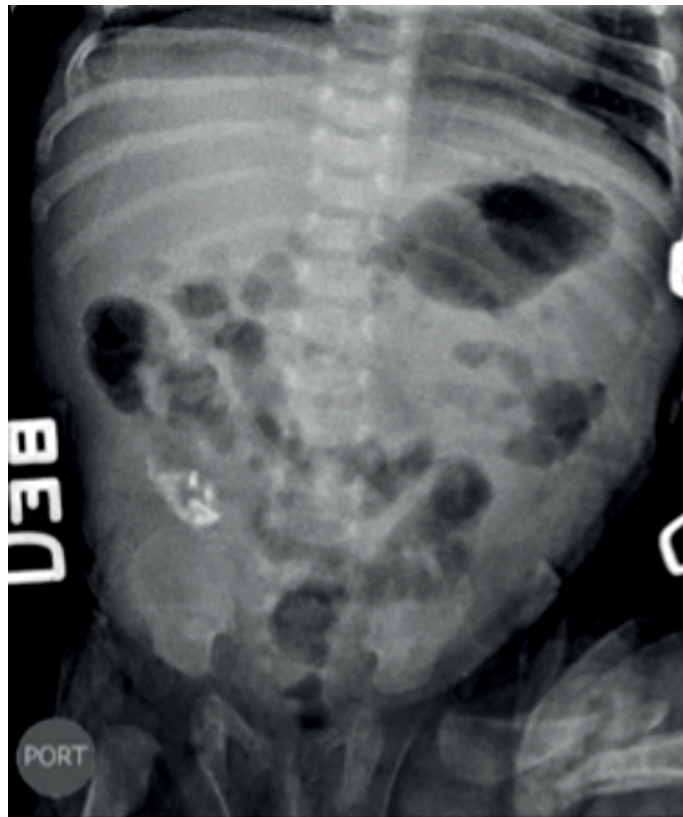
Abdominal x-ray. 42 mm x 41 mm calcified mass with signs of possible partial intestinal obstruction.
